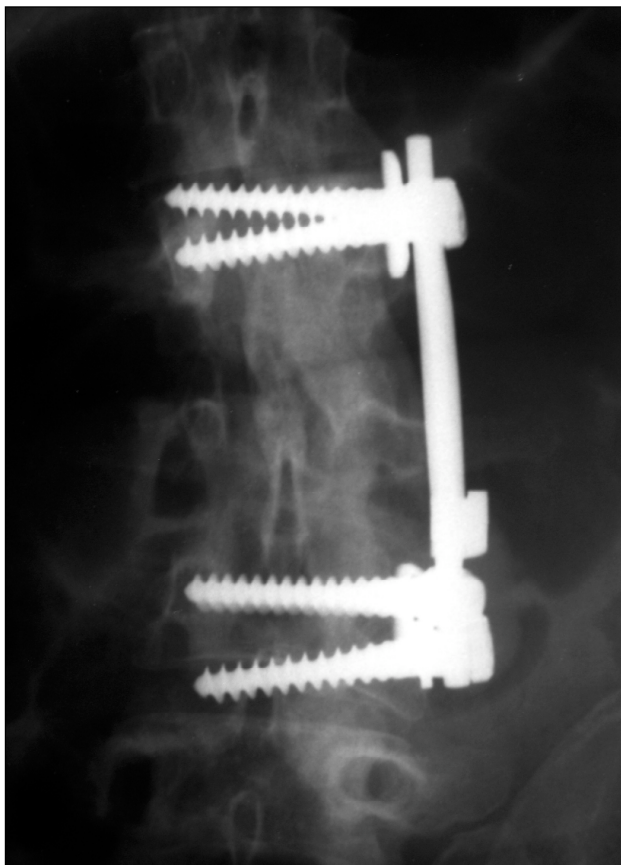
Anteroposterior lumbosacral radiography of the patient showing the anterior plate between L2 and L4 bodies.
